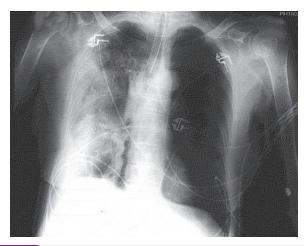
Radiologic diagnosis of pneumonia. A standard posteroanterior radiograph in a 70-year-old woman demonstrates chronic obstructive pulmonary disease complicated by right multilobar *Streptococcus pneumoniae* pneumonia and empyema.
